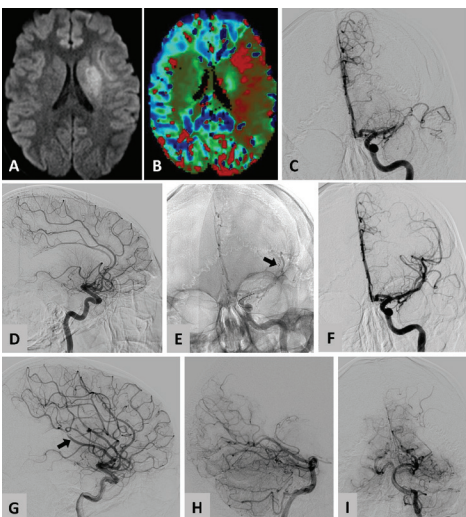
In Case 2, (A) MRI diffusion weighted imaging shows a relatively small area of core infarct involving the left basal ganglia and (B) a large area of hypoperfusion on time-to-peak perfusion sequences, consistent with a large area of ischemic penumbra in the left MCA distribution. (C) DSA AP and (D) lateral views show a left MCA occlusion at the M1 segment. (E) DSA AP native view with a Solitaire retrievable stent (Covidien, Plymouth, MN) deployed shows distal tines of the stent to be in the anterior division of the left MCA (arrow). (F) Post-thrombectomy DSA AP and (G) lateral views show complete recanalization of the anterior and partial recanalization of the posterior division of the left MCA. There is stagnant flow in the posterior division of the left MCA (arrow). (H) Post-thrombectomy DSA AP and (I) lateral views of left vertebral artery injections show good leptomeningeal collateral circulation provided to the posterior division of the left MCA territory via the left posterior cerebral artery.
